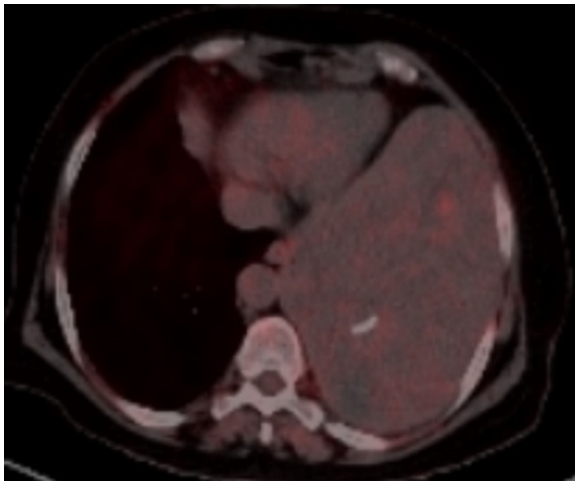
The positron emission tomography scan revealed low-grade diffuse fluorodeoxyglucose (FDG) uptake in the mass (maximum standardized uptake value/max SUV 2.3).
